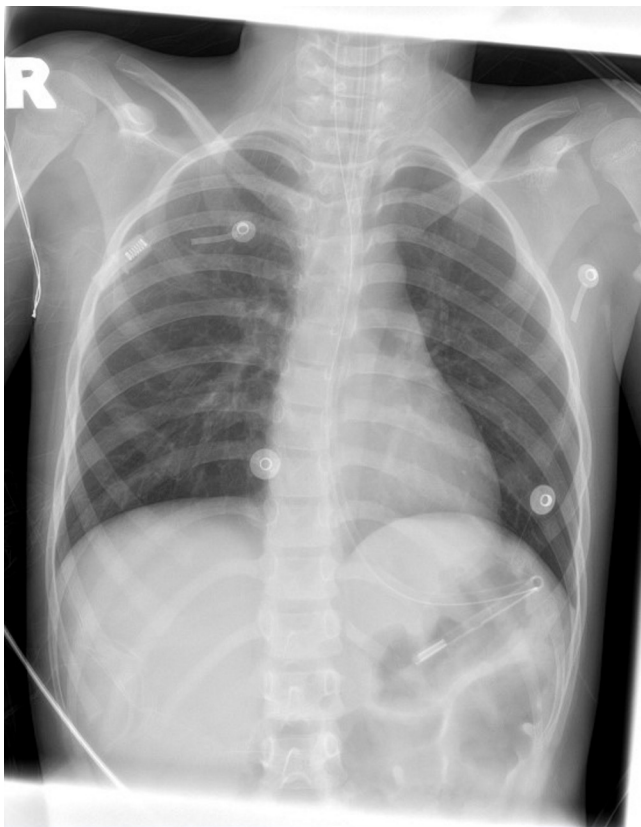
Chest radiography done on the day of admission was unremarkable.
